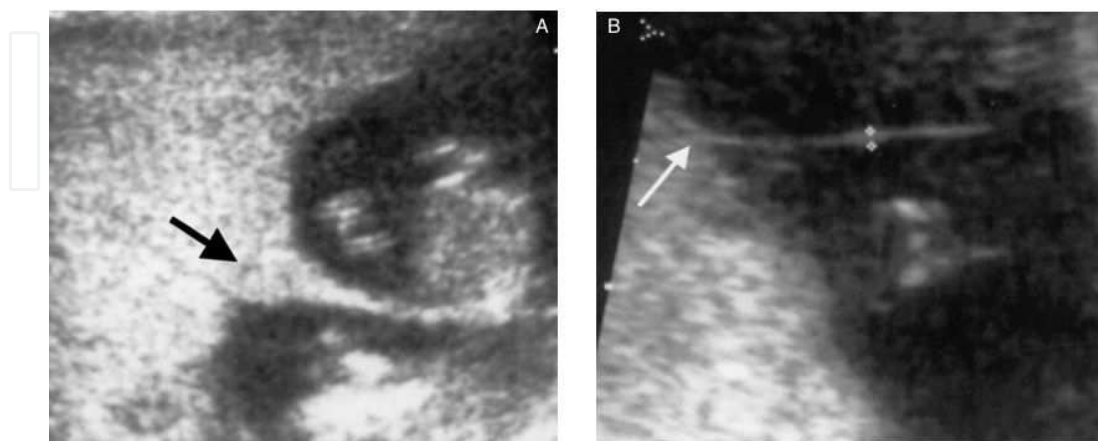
First trimester ultrasound image of a fused dichorionic placenta with lambda sign (A) and first trimester ultrasound image of a monochorionic placenta with T sign (B). Adapted from *BJOG, Carroll et al.* [38], with permission from the publisher.
